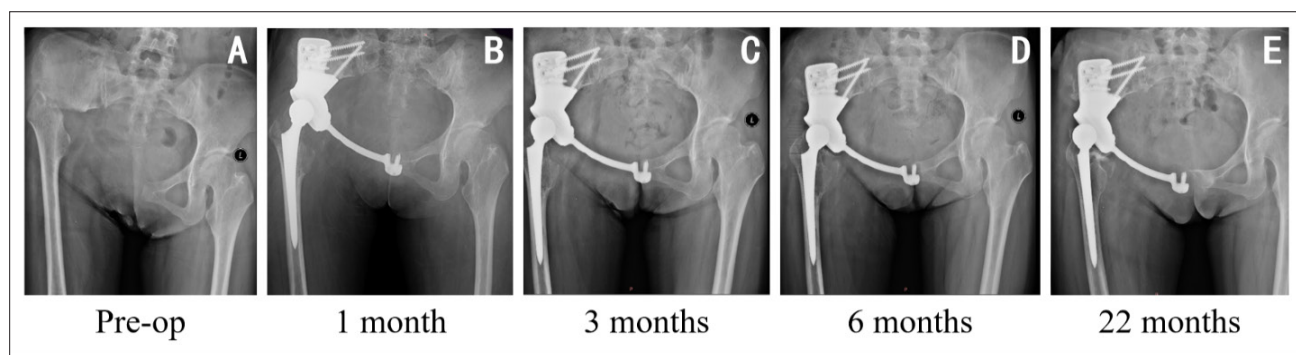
X-ray images of a middle-aged female with a pelvic defect at different time points (A) before and (B–E) after surgery: (B) 1 month, (C) 3 months, (D) 6 months, and (E) 22 months. The tantalum-coated prosthesis remained stable within a year after surgery. Abbreviation: Pre-op, preoperation.
